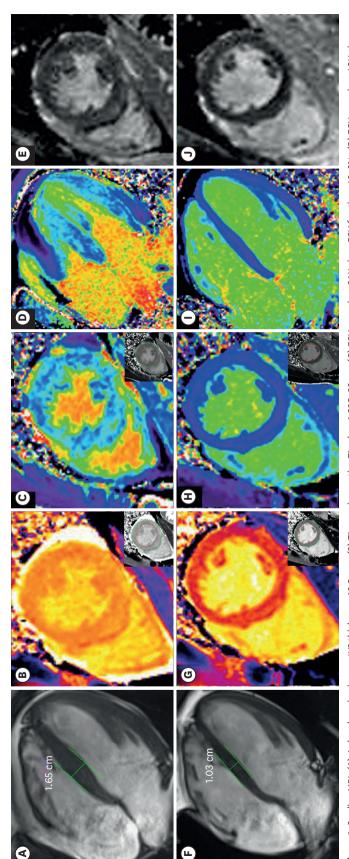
Cardiac MRI: (A) 4 chamber cine image, IVS thickness: 16.5 mm; (B) T1 mapping, native T1 value: 1,505±82 ms; (C) ECV mapping, SAX view, ECV fraction: 40±3%; (D) ECV mapping, 4CH view, ECV fraction: 40±4%; (E) LGE image, mid-LV: diffused spotty LGE; follow-up cardiac MRI: (F) 4 chamber cine image, IVS thickness: 10.3 mm; (G) T1 mapping, native T1 value: 1,287±81ms; (H) ECV mapping, SAX view, ECV fraction: 24±3%; (I) ECV mapping, 4CH view, ECV fraction: 25±6%; (J) LGE image, mid-LV: no LGE. ECV fraction: 24±3%; (I) ECV mapping, 4CH view, ECV fraction: 25±6%; (J) LGE image, mid-LV: no LGE. ECV fraction: 24±3%; (I) ECV mapping, 4CH view, ECV fraction: 4CH view, EC
